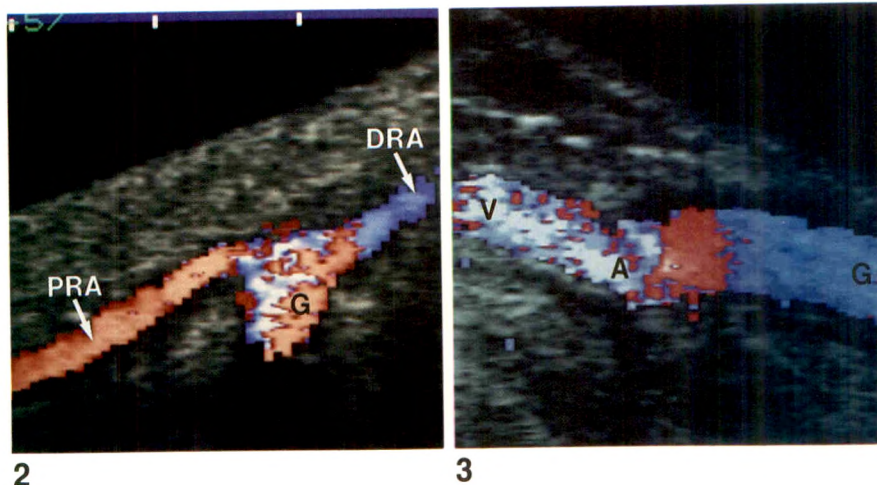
Normal venous anastomosis. Longitudinal color Doppler sonogram shows anastomosis (A) between synthetic graft (G) and draining vein (V).
